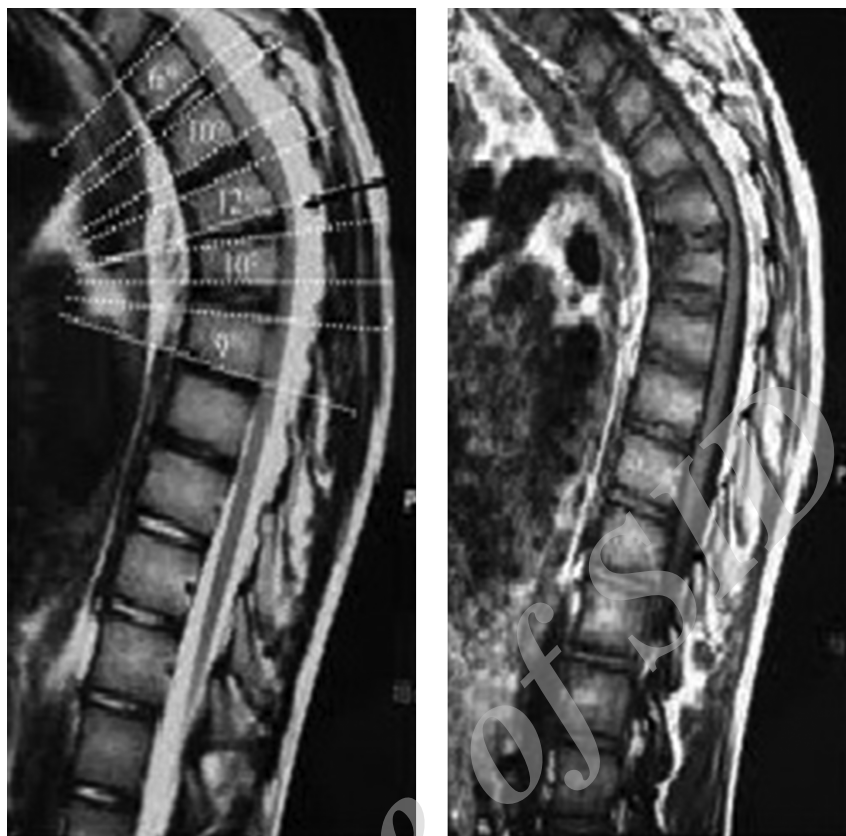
Sagittal magnetic resonance imaging of a 14-year-old female with typical Scheuermann's disease
